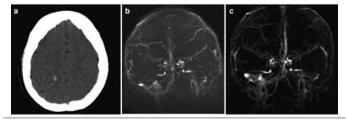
a. Cerebral CT: two small cortical haemorrhages on the right hemisphere. b. Cerebral MRA: total occlusion of the superior sagittal sinus, of the left lateral sinus and reduced perfusion of the rectum sinus. c. Follow-up cerebral MRA, performed 14 days after diagnosis restored venous blood flow in the superior sagittal sinus and in the rectum sinus.
